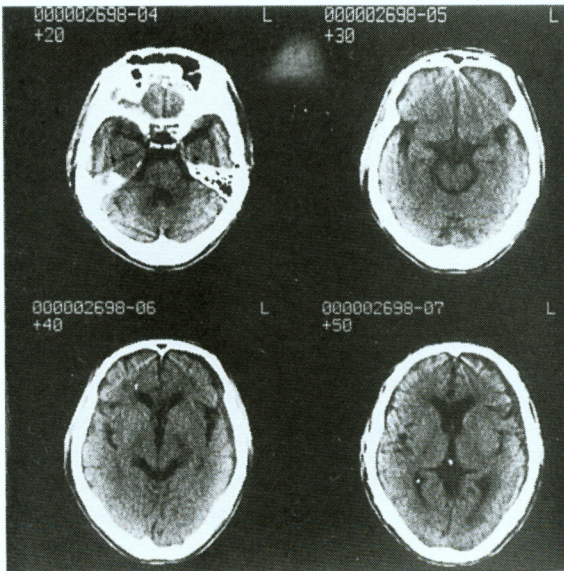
Precontrast CT scans showing diffuse cerebral atrophy ventricular dilatation, and prominent cerebellar folial markings.
